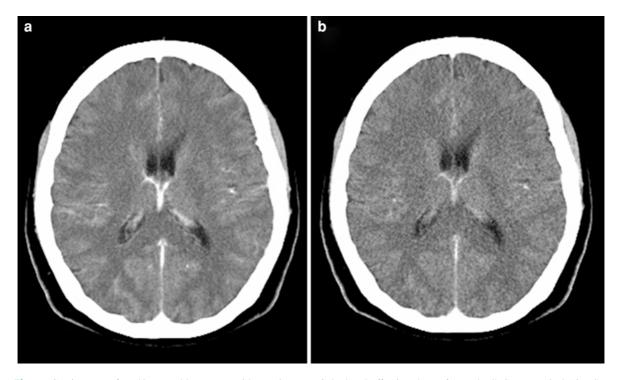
CT images of a 43-year-old woman with persistent headache since 3 weeks show normal brain structures at the level of lateral ventricles. Standard brain CT after I.V. iodine contrast with a 6-MDCT at 130 kV, 280 mAs, 1 s rotation, CTDI = 61.2 mGy, comparable to the 'EU reference level'.
